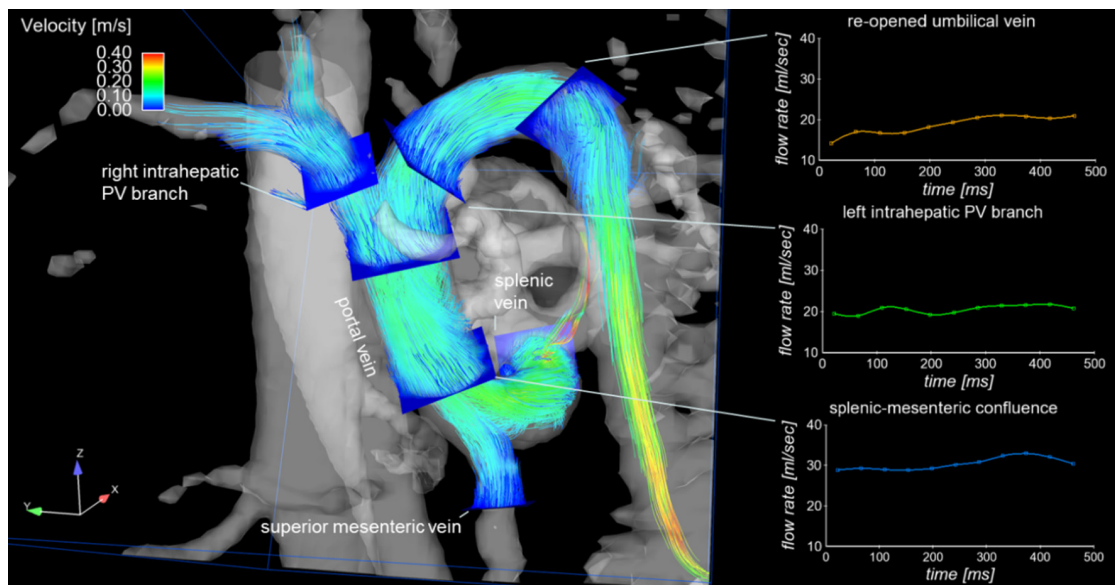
4D flow MRI visualization of the hepatic hemodynamics by 3D pathlines in a 50-year-old female patient with advanced liver cirrhosis Child-Pugh class B. Analysis planes were positioned in the splenic and superior mesenteric veins, splenic-mesenteric confluence, right and left intrahepatic portal vein branches and the proximal part of the portosystemic shunt represented by the umbilical vein. Pathlines reveal normal flow in the extrahepatic portal venous system. A reopening of the umbilical vein fed via the left branch of the intrahepatic portal vein is shown with an increase of flow velocity within the umbilical vein. Graphs on the right side show flow-time curves of the splenic-mesenteric confluence, left intrahepatic portal vein branch and the re-opened umbilical vein.
